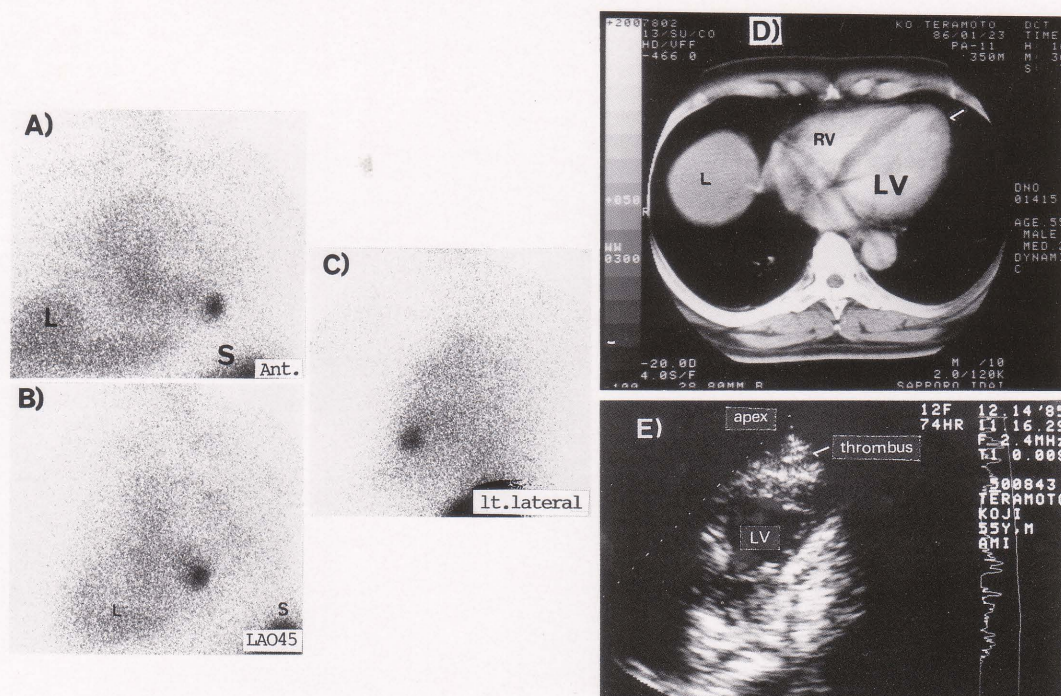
Broad anterior infarction, apical aneurysm (K.T. 55-year-old male). Indium-111-labeled scintiphoto, CT and echocardiography reveal mural thrombus in the apical region of the LV (Indium-111 platelet scan: A; Anterior view, B; Left anterior oblique view, C; Left lateral view). After these examinations, antiplatelet therapy (Ticlopidine; 300 mg/day) was performed.
